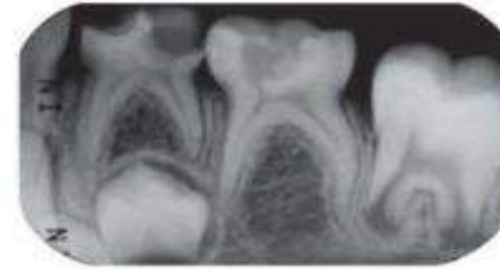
Preoperative periapical radiograph of the mandibular left primary molars of a 6-year old girl, which presented extensive caries lesions, two thirds or more of root length, and no signs of periapical lesion. Agensis of the mandibular left permanent second premolar was observed
